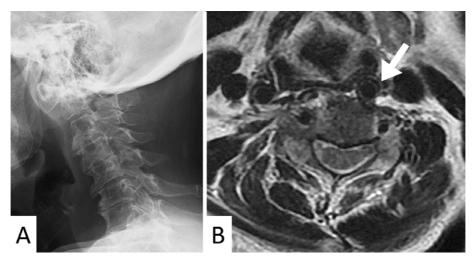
A, B. Example of a left-sided Grade 3 anomaly in a 72 year-old female. (A) Cervical lateral radiograph in sitting position shows kyphotic alignment (cervical lordosis: -5°). (B) Axial MRI shows the severe medialization of the left common carotid artery located in front of the C5 vertebral body (white arrow).
